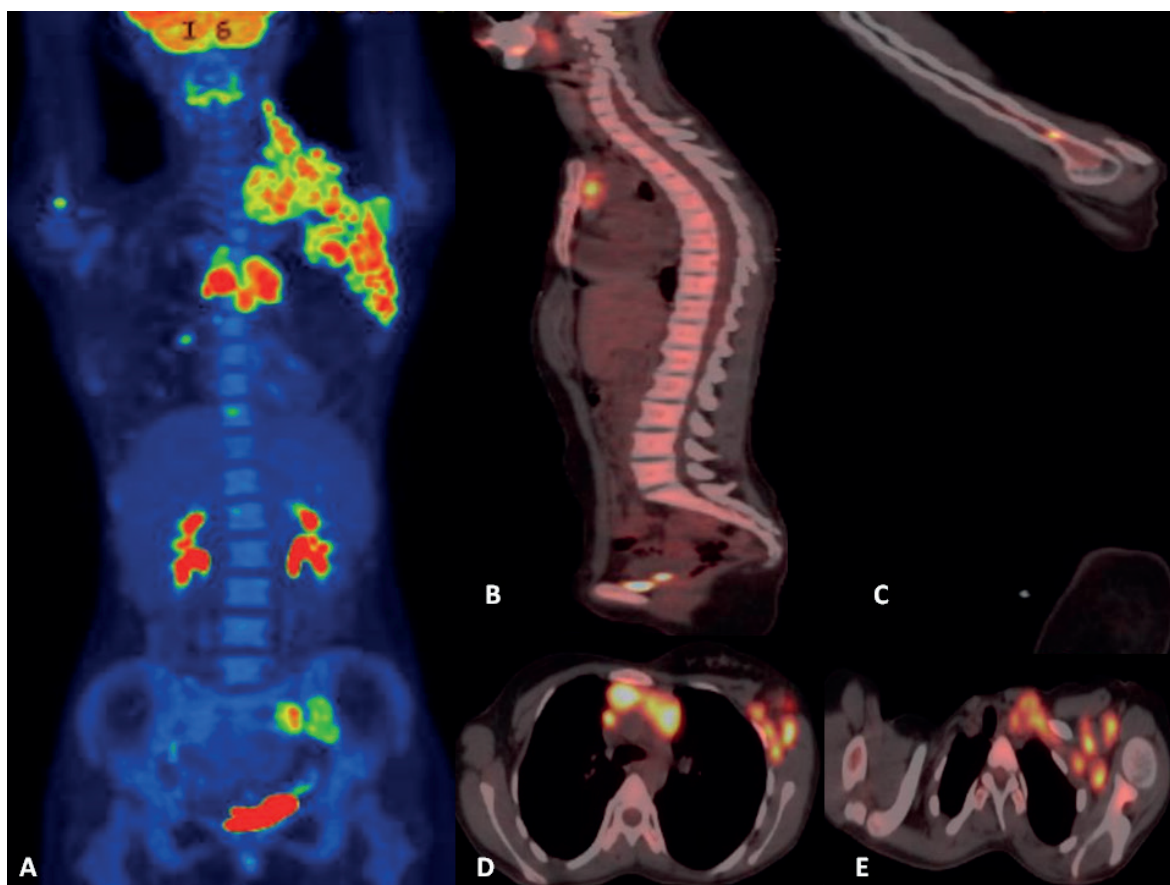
FDG PET-CT images of a 15 year old female patient with Hodgkin Lymphoma diagnosis. Maximum intensity projection (MIP) image (A), sagittal (B, C) and axial (D,E) fusion images demonstrate multiple hypermetabolic lymphadenopathies and bone-bone marrow diffuse and multifocal FDG uptake compatible with lymphoma diagnosis. Bone marrow biopsy was negative for this patient.
